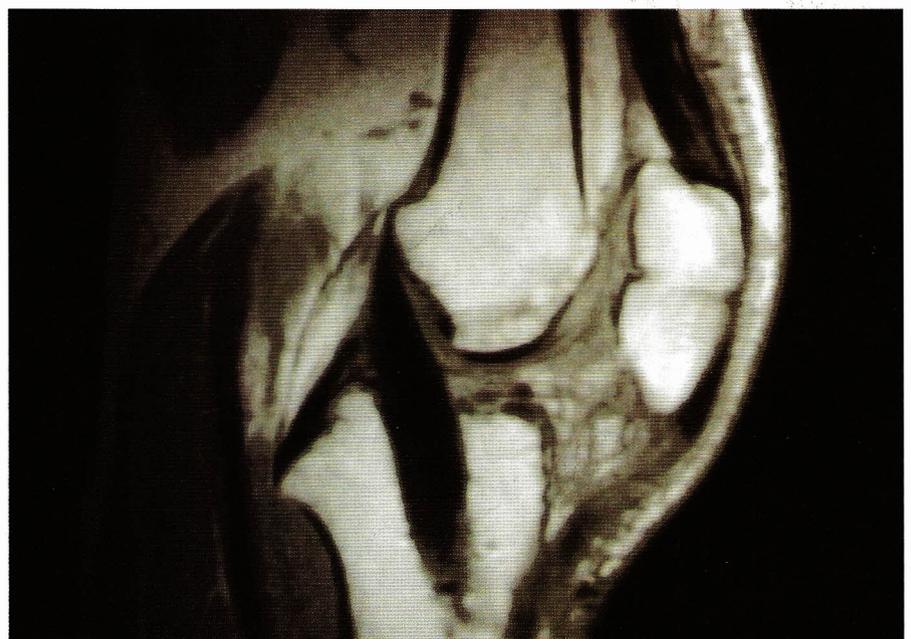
Axial MRI scan in the same patient, showing a.p. graft alignment, with formation of an anteromedial and a posterolateral bundle.
